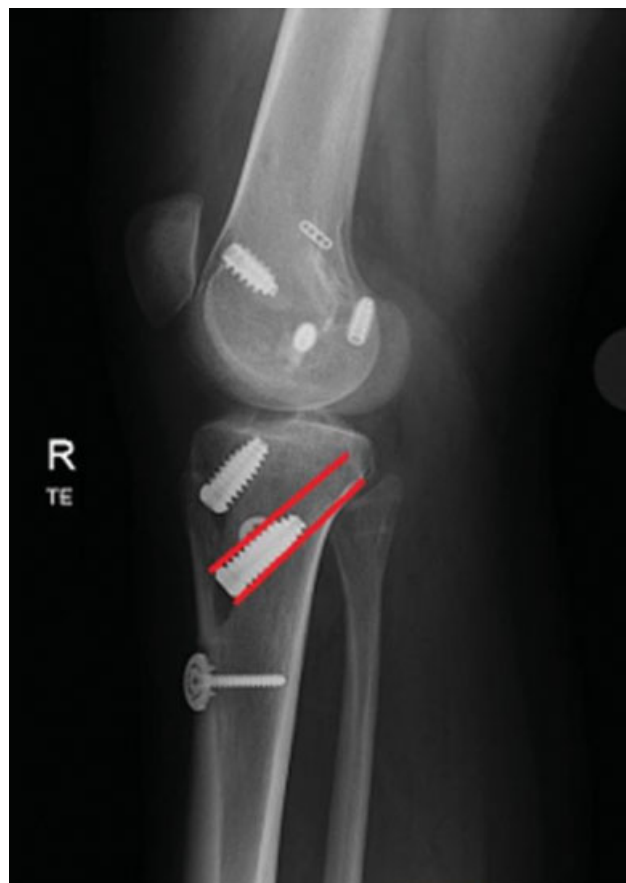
Lateral knee radiograph showing appropriate tibial tunnel placement low on the posterior cruciate ligament facet to create a better lever arm.
